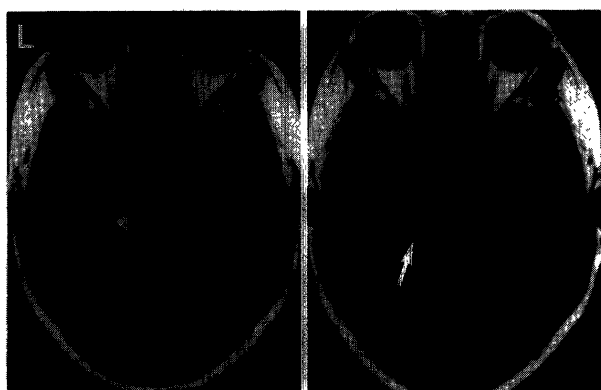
Case 1. *left*: T<sub>1</sub>-weighted SE MR image, showing a high-intensity lesion, representing the hematoma, near the root entry zone of the left trigeminal nerve. *right*: T<sub>1</sub>-weighted SE MR image 1 month later, showing a small low-intensity lesion at the same location (arrow).
